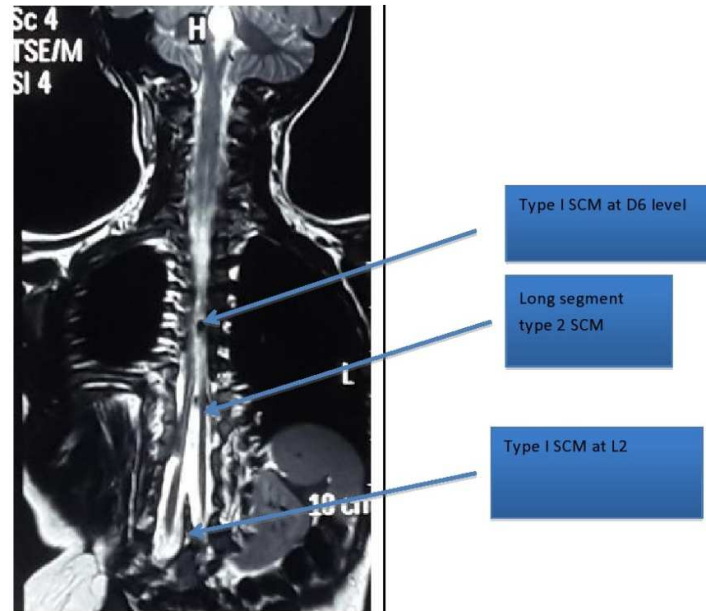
MRI Spine coronal sections showing long segment splitting of cord extending from D5 vertebral level to L4 vertebral level with double bony spurs
